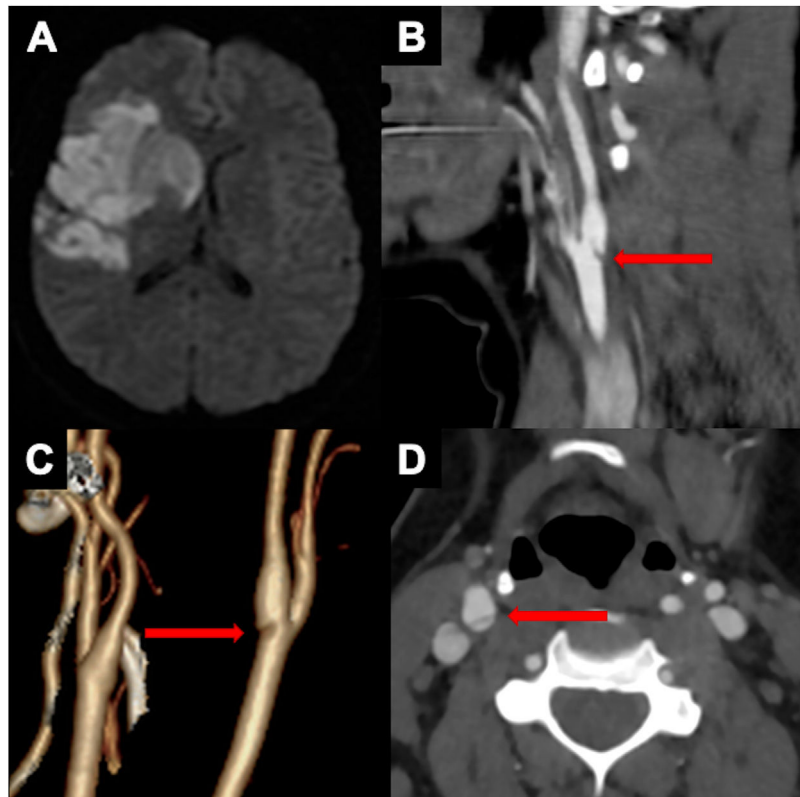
(A) Diffusion-weighted magnetic resonance imaging shows an infarction in the frontal and temporal lobes, also affecting the basal ganglia. (B and D) Computed tomography angiography demonstrates a thin intraluminal filling defect (arrow) along the posterior wall of the right carotid bulb which appeared as a septum on axial image. (C) A postero-lateral view of the 3D reconstruction computed tomography angiography shows the web like an indentation of the carotid wall.
